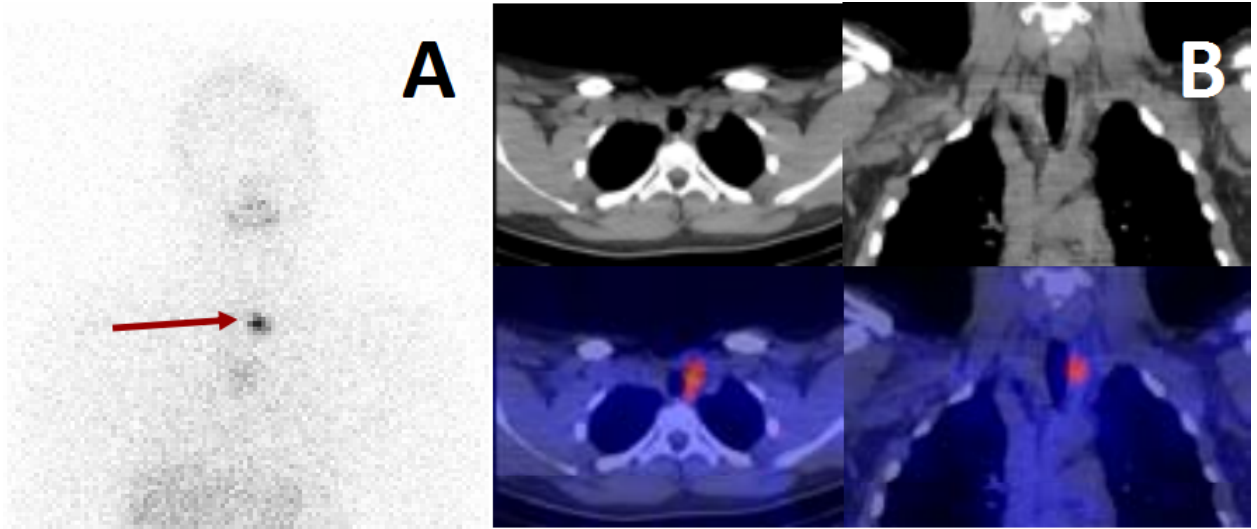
^{131}I scan of thyroid cancer (red arrow) A: Planar Scintigraphy and B: SPECT/CT (12)
